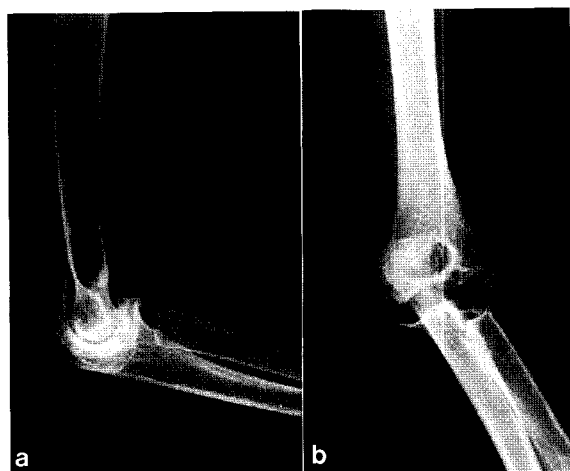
X-ray 5 years after synovectomy. a: Antero-posterior view; b: Lateral view.
